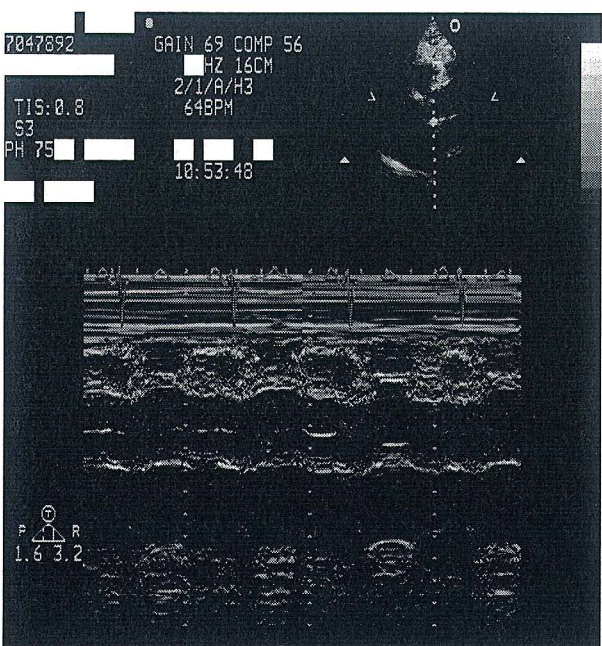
Cardiac M-mode ultrasound image. Some ID tags are located in different positions when compared to the B-mode standard view
